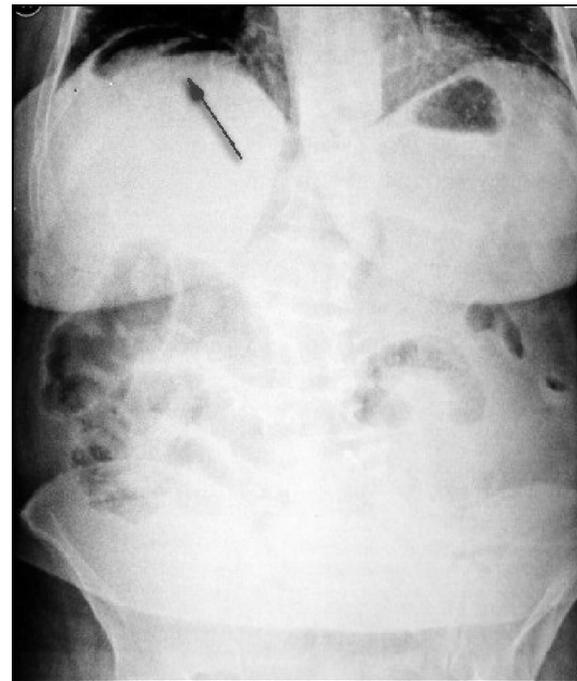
Plain abdominal radiography showing of free air beneath the right leaf of the diaphragm
